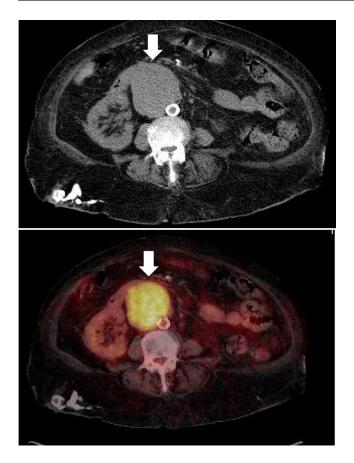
Follow-up PET-Scan 16 months after the first one shows interval progression of the pericaval retroperitoneal mass (arrows) measuring up to 7.5 cm with SUV max of 10, with no evidence of metastatic adenopathy, liver or bone disease.
